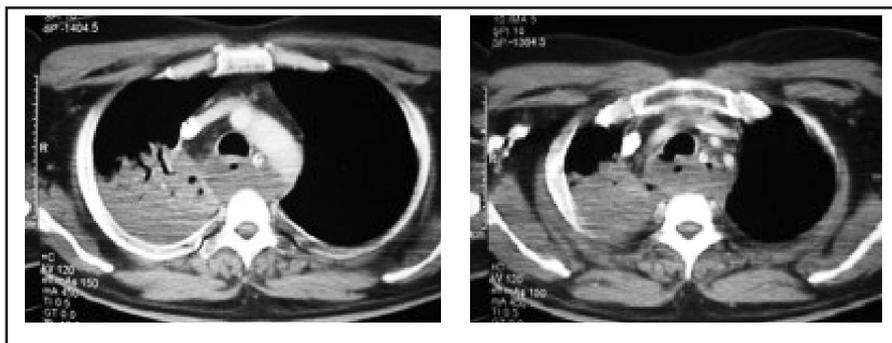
CT scans of the thorax reveals diffuse edema with air-fluid cavity surrounding the thoracic esophagus
